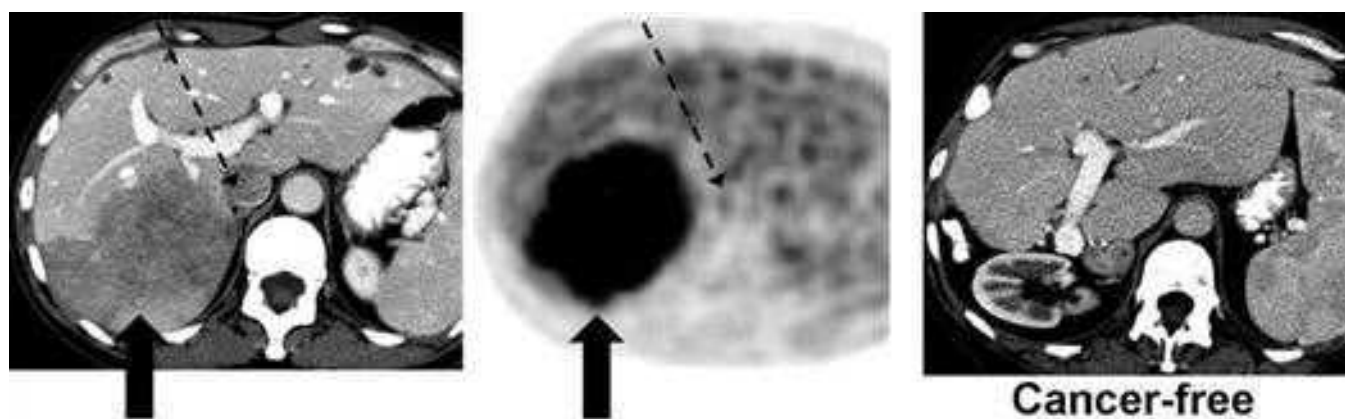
Computed tomography (CT)–positron emission tomography (PET) scans before and after resection of liver metastasis from colorectal cancer in a 54-year-old patient. CT scan shows large 10-cm right lobe liver metastasis (*left panel*), and PET scan findings are strongly positive (*middle panel*). Two years after right hepatectomy, the patient has no evidence of recurrence and significant hypertrophy of the left lobe (*right panel*).
